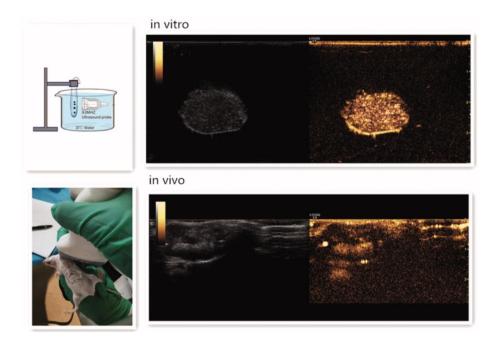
Ultrasound enhancement images of nanodroplets in vitro and in vivo (copyright from Zhou *et al.*¹⁰²)
